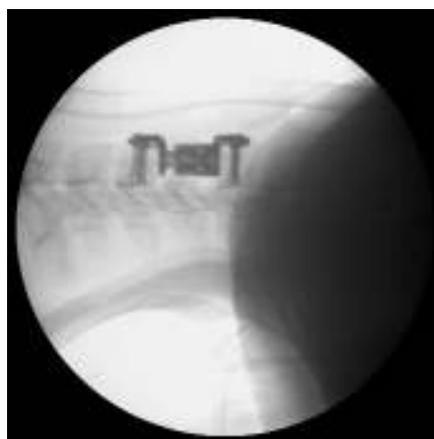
X-ray with vertebral prosthesis with no additional plate
